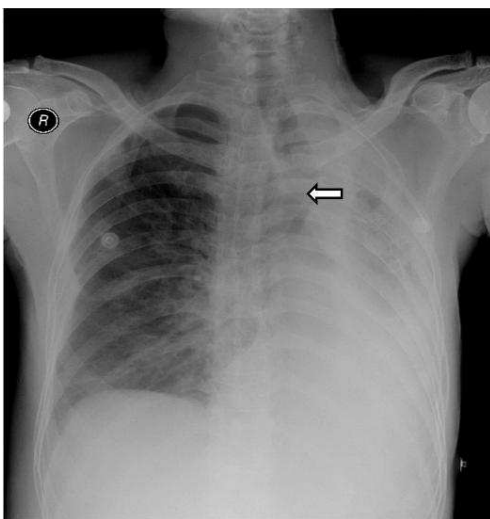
Chest X-ray on the fourth postoperative day- opacification of the entire left hemithorax with an ipsilateral mediastinal shift (arrow), proximal air bronchogram, crowding of ribs, and obscuring of diaphragm and heart borders were highly suggestive of lung collapse due to mucus plugs.
